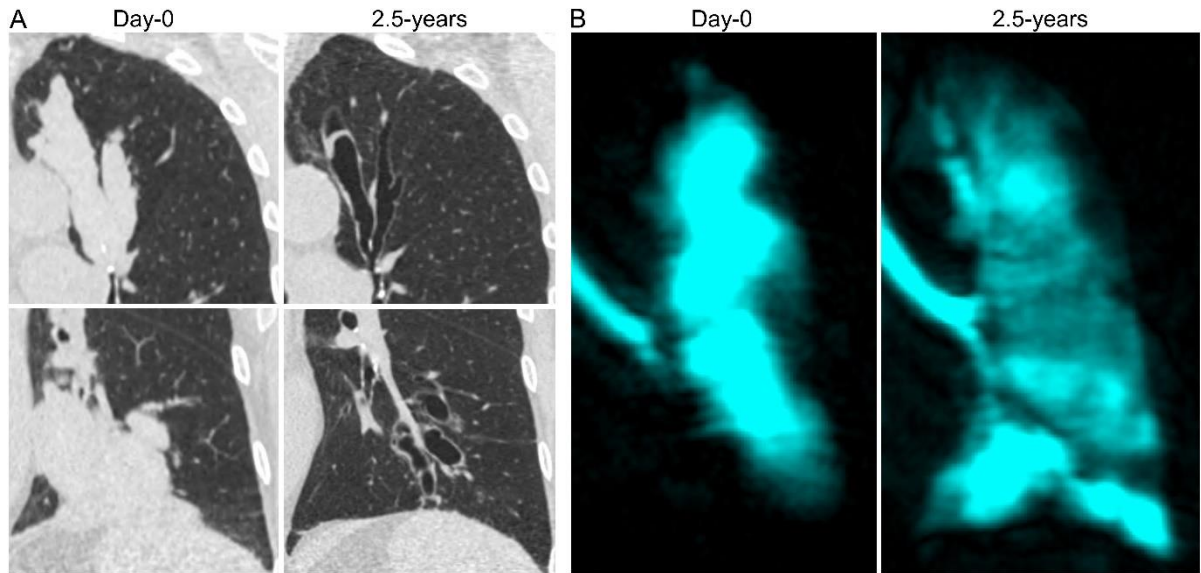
CT mucus-occlusion and MRI ventilation improvement at 2.5-years
